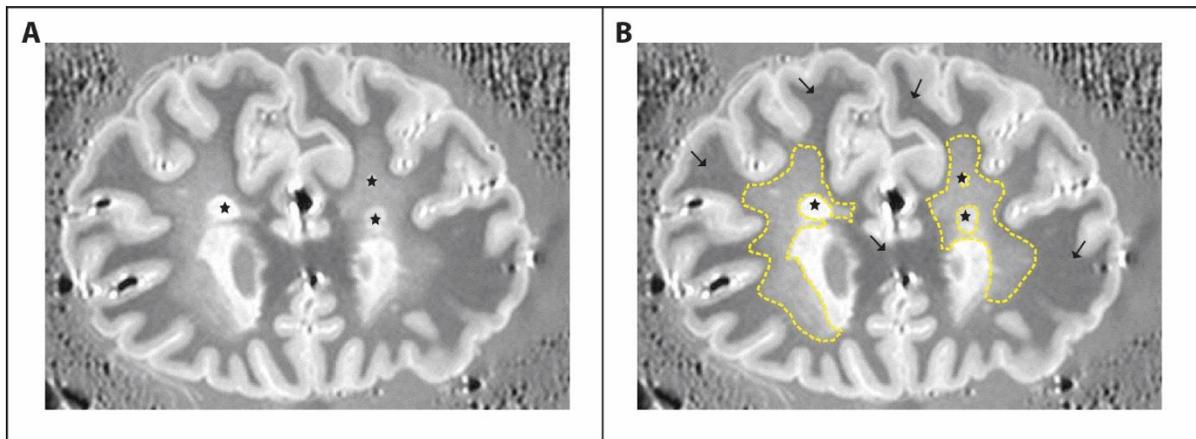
Diffusely abnormal white matter in MR imaging. A) A proton density scan of formalin-fixed paraffin-embedded brain tissue, showing distinct lesions (stars). B) The diffusely abnormal white matter (outlined with yellow dashed lines) surrounding the lesions is a region of intermediate intensity when compared to the lesion and the distant normal appearing white matter (arrows). Images courtesy of Dr. Cornelia Laule.
